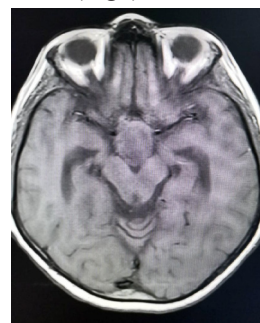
1 MRI T1 Isointense space occupying lesion in Sellar space
